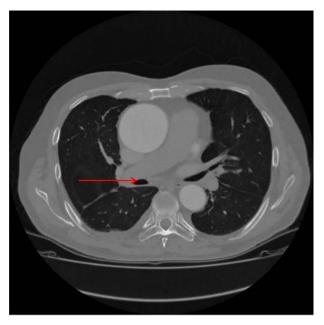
Cross-sectional CT image demonstrating ascending aortic aneurysm with associated mild to moderate right bronchus intermedius compression (red arrow indicates right bronchus intermedius). Image represents the lung window.
